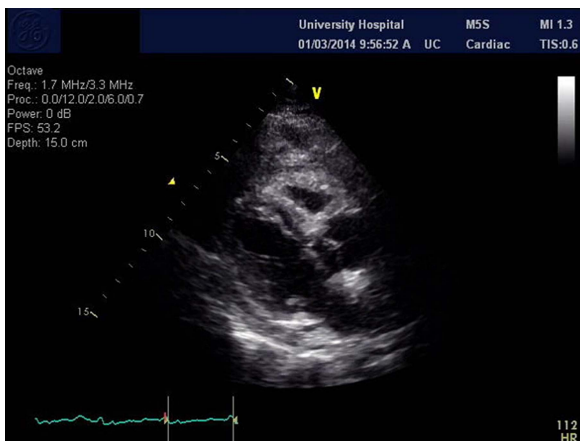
Parasternal short access demonstrating the mass also encasing right ventricular outflow tract (arrow; RA, right atrium; RV, right ventricle).
